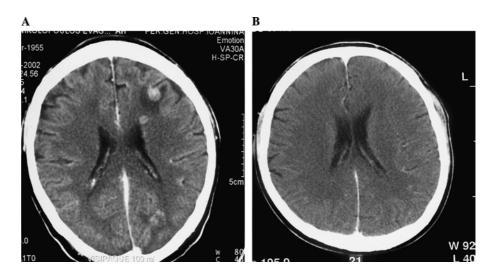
Complete response of brain metastases following four cycles of ECI therapy in a patient treated at 120 mg/m² irinotecan dose level (a CT scan, pretreatment; b CT scan
